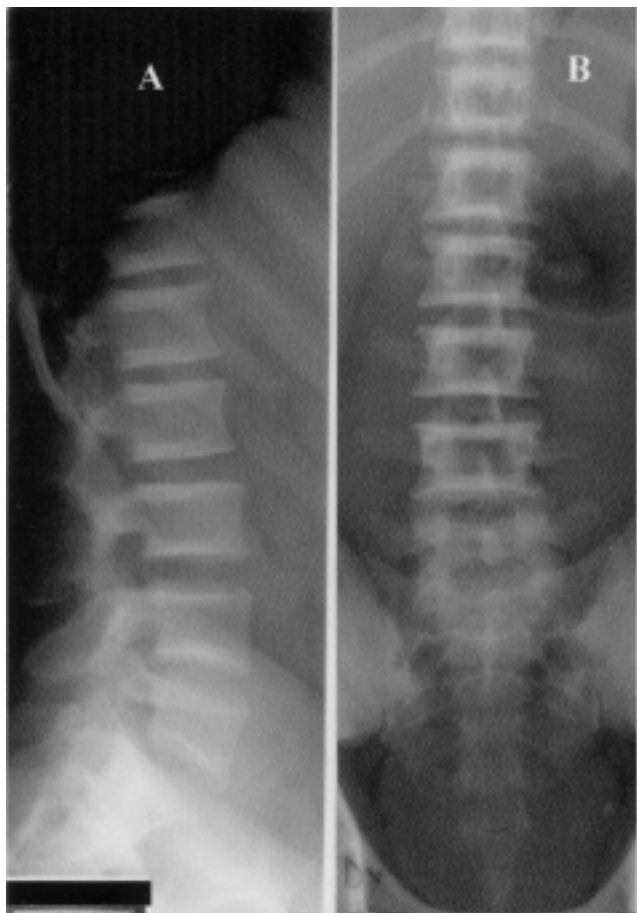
X-ray of the vertebral column shows bone sclerosis, which is a characteristic radiological sign of OP.
